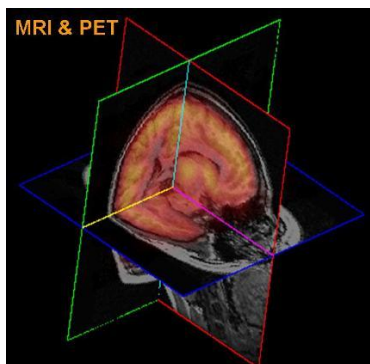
Example of volume image fusion of MRI and PET scans using orthogonal dissection with color-mix pixels.
